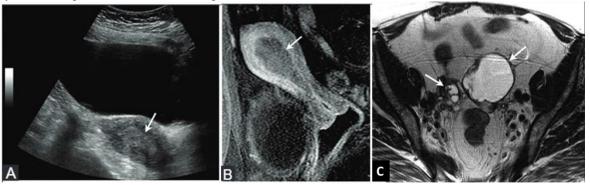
(a) Ultrasound, (b) PET and (c) MRI image of Utereus with Stage III EC adopted with permission from Ref [4].
